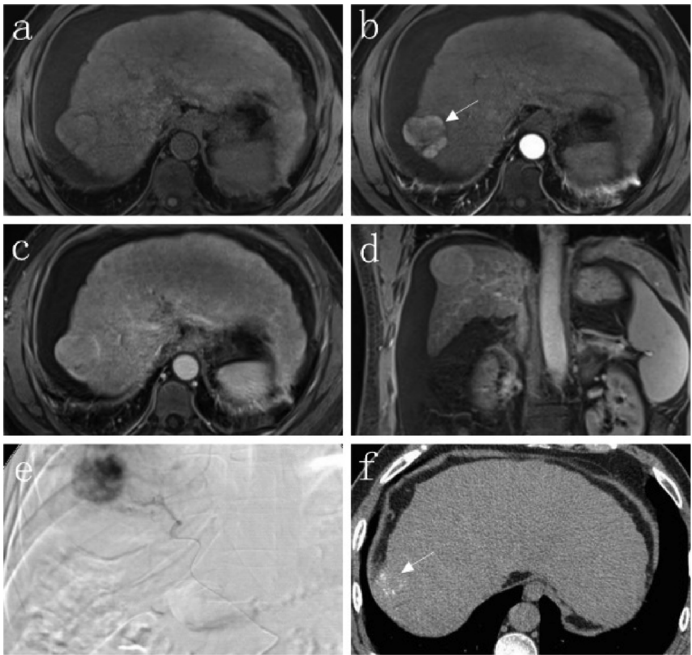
LR-5 nodule and TACE outcome. T1-weighted (A) and T1-weighted post-contrast arterial phase (B, C, D) MRI showed a nodular external contour of the liver in segment 7 with hypervascularity on DSA (E), representing hepatocellular carcinoma. 2 months later, dispersed lipiodoldeposits were noted (F).
